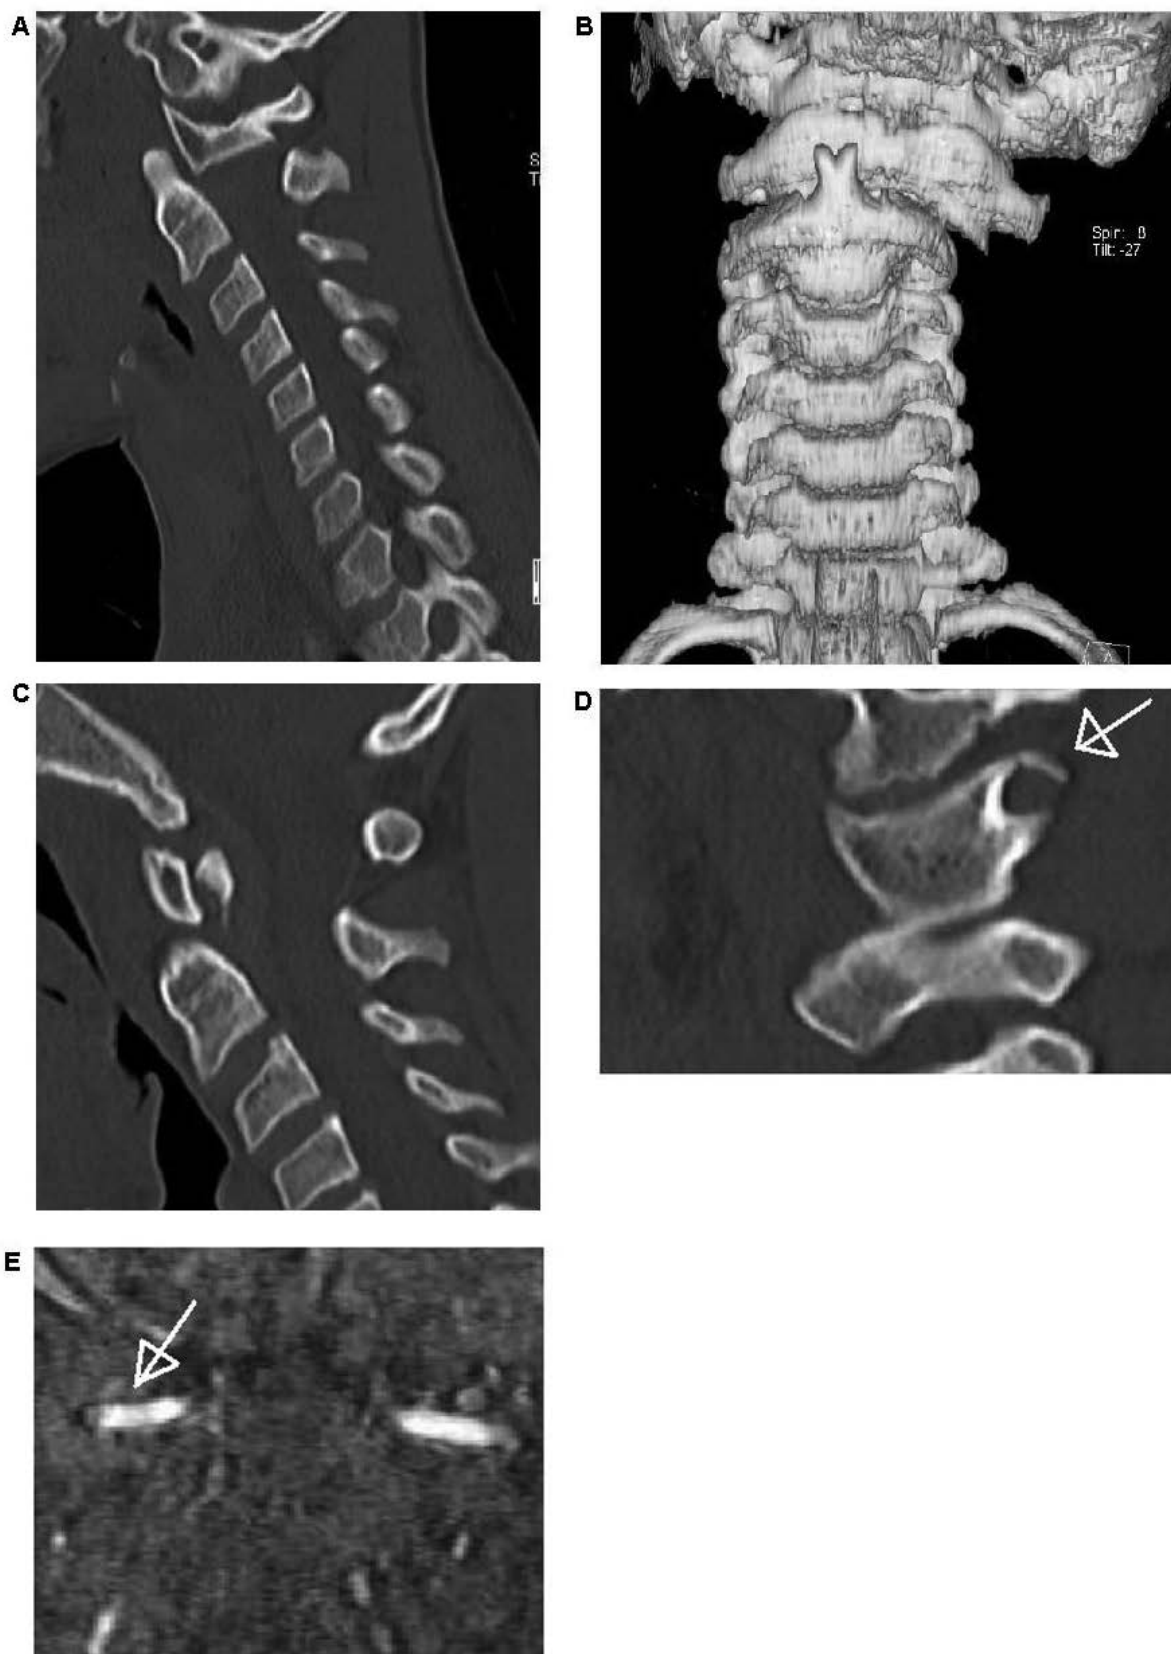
C1/C2 dislocation with combined dens fracture: A) sagittal cervical computed tomography (CT) showing the anterior dislocation of the dens axis; B) 3D reconstruction of the preoperative cervical CT; C) the fractured dens axis is shown; D) the vertebral foramen seemed to be injured, too (arrow); E) to exclude any lesions of the vertebral artery a CT angiography has been performed. No dissection of the vertebral artery could be seen (arrow).
